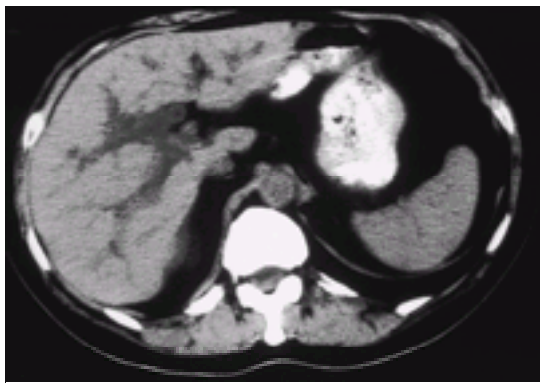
CT scan of the liver showing grossly dilated bile ducts.
